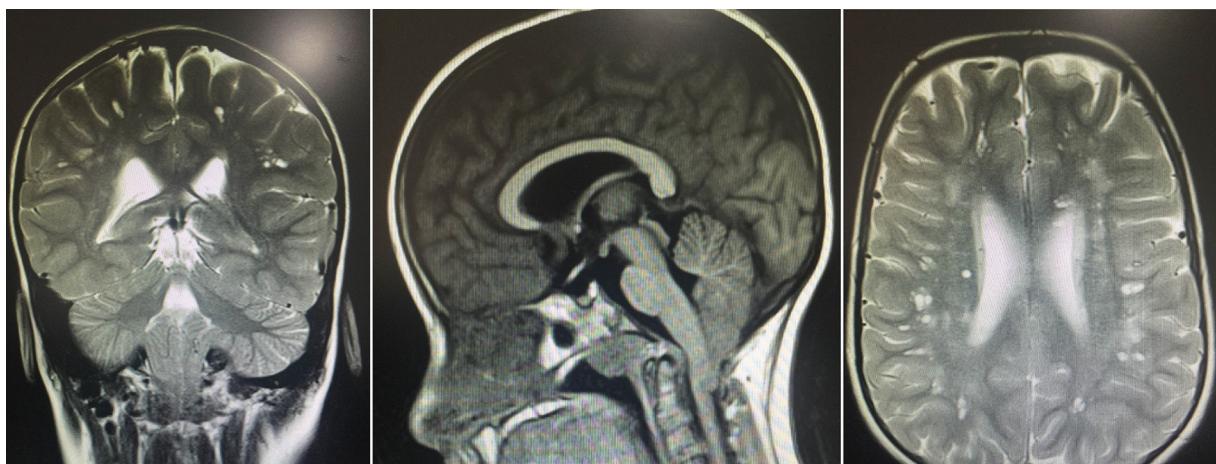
Brain MR images showing multiple lesions, especially in the subcortical white matter bilaterally, resembling small spaces with CSF-like behaviour in all sequences, and hyperintense areas, some surrounding the lesions, giving the brain a spongiform appearance. The images also show moderate downward displacement of the cerebellar tonsils through the foramen magnum (type I Chiari malformation with no morphological changes).
